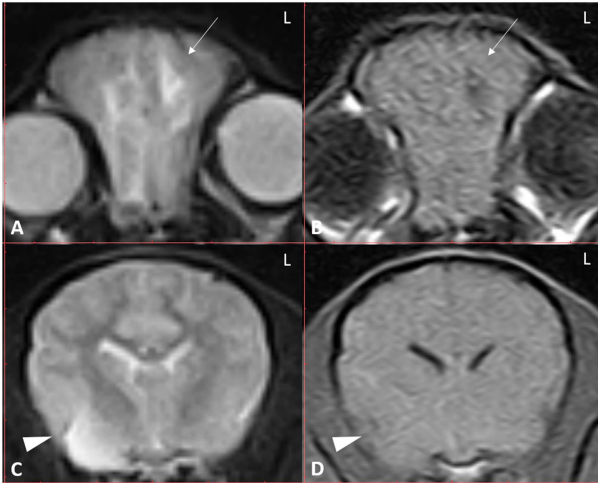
MRI findings at initial presentation. A, C: Transverse T2-weighted images. B, D: Transverse T1-weighted images. On T2-weighted images, multifocal ill-defined, hyperintense lesions are noted in the frontal lobe (arrow) and temporal lobe (arrowhead). The same lesions produced iso- to hypointense signals on T1-weighted images.
